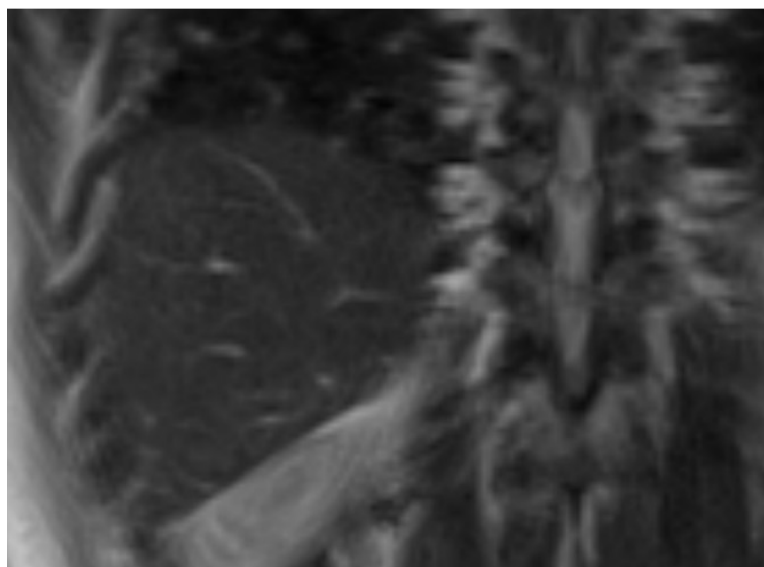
Coronal T2 MRI region of the area of raised stiffness in Figure 12, showing no focal lesion, as this is sometimes a cause of elastogram ‘hot spots’
